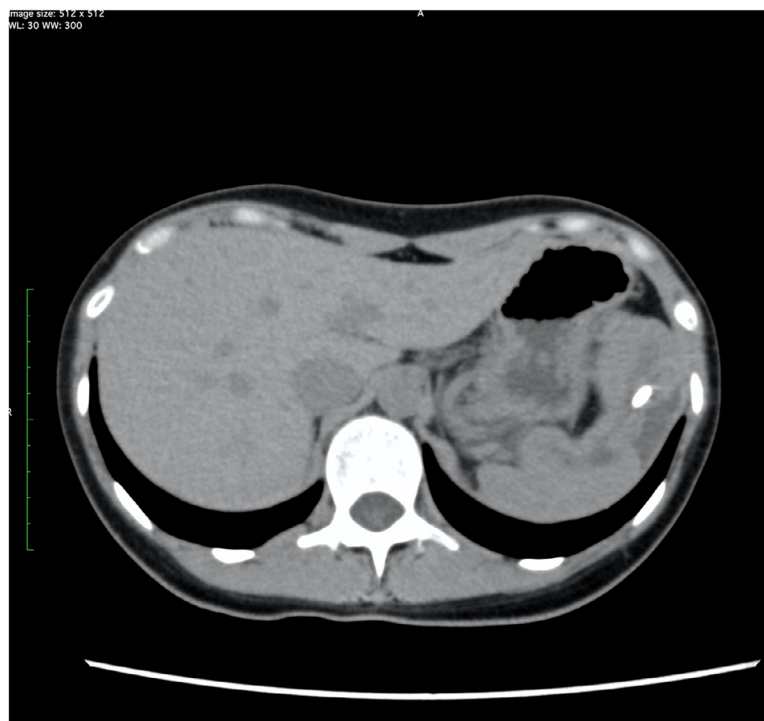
Computed tomography performed 1 day after second session shows that the cyst is completely collapsed.
